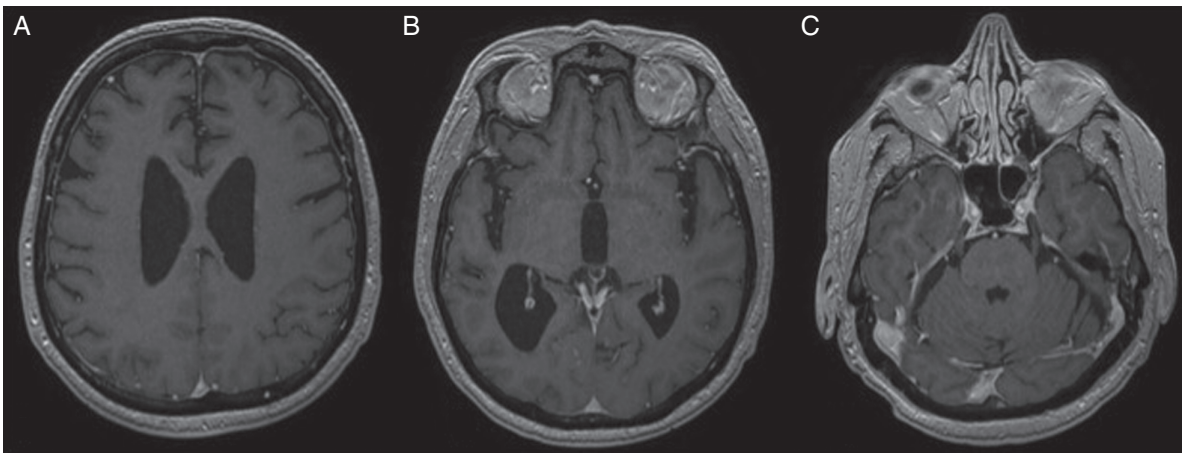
(a-c) Axial T1 post-contrast MRI brain studies showing total resolution of leptomeningeal disease after treatment following recurrence.
